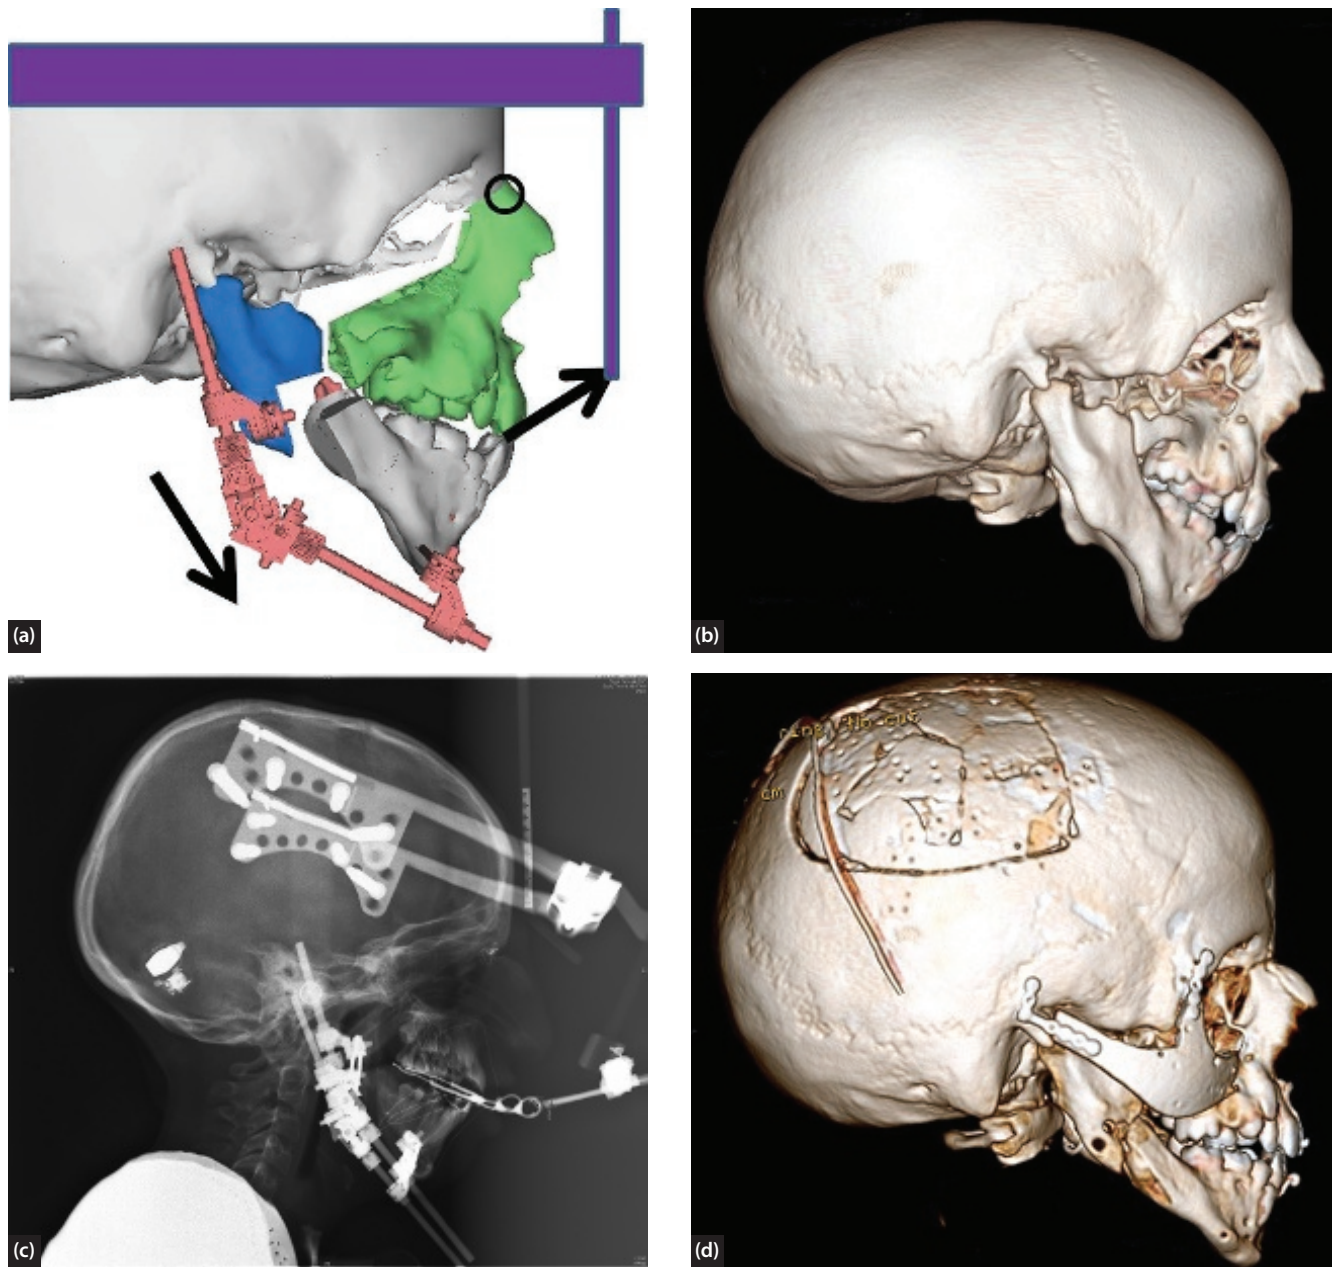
(a) Combination distraction osteogenesis allowing for lengthening of the mandible and rotation of the maxilla–mandibular plane angle (by use of a nasion cerclage wire and traditional rigid external distraction to correct the occlusal plane). Image © Dr Richard Hopper MD. (b) Pre-operation. Steep mandibular occlusal plane angle with vertical mandibular growth pattern resulting in reduced retroglossal airway space. (c) Active distraction phase with combination RED (rigid external distractor) frame and mandibular distraction. (d) Post-operative 3D CT showing significant change in pogonion (chin point), normalization of occlusal plane angle and dentition. Calvarial onlay grafts used to reconstruct hypoplastic zygomatic arches. Photographs courtesy of Dr Richard Hopper MD, Seattle, Washington.
